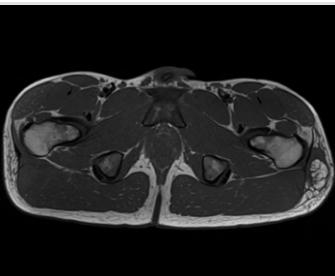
T1-weighted axial magnetic resonance imaging slice showing the fat fracture in the adipose tissue between the subcutaneous tissue and fascia of the left thigh.
